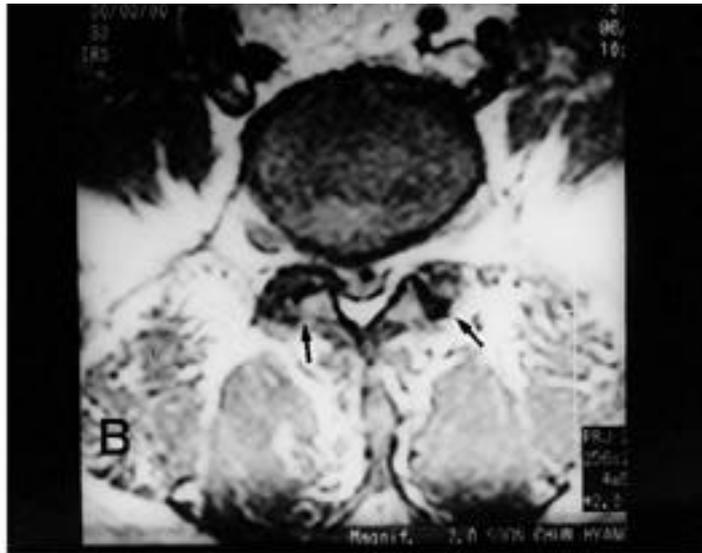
T2 weighted sagittal and axial MR images show the herniated intervertebral disc at L4-5, L5-S1 level and a low signal intensity area in the left pars interarticularis of L5 (arrow head).
